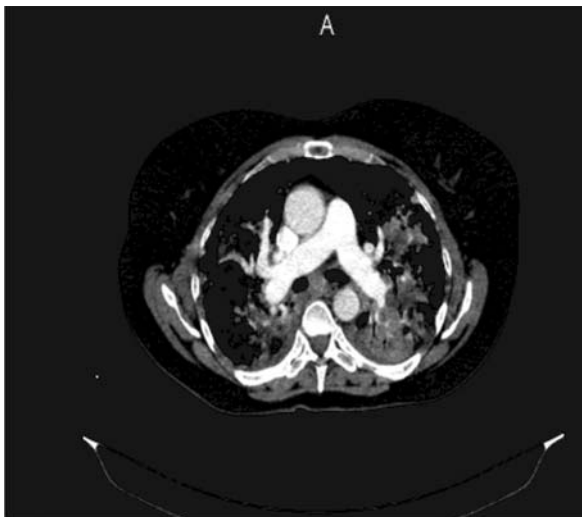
CT of patient's lungs arteries
